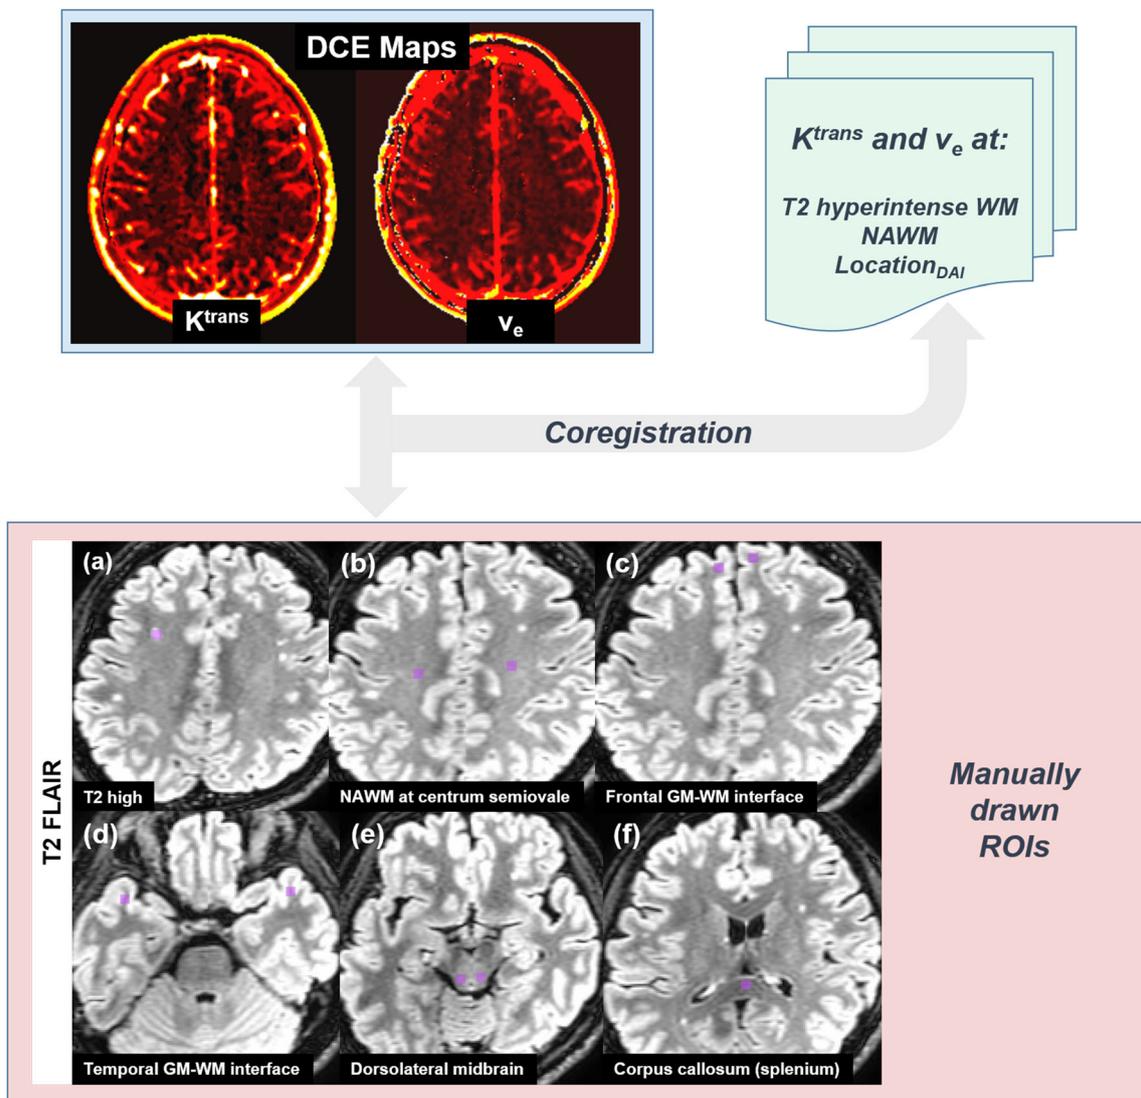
Image analysis of dynamic contrast-enhanced (DCE) MR Imaging. DCE MR imaging pharmacokinetic parameter maps (K^{trans} and v_e) are coregistered with T2 FLAIR images to obtain K^{trans} and v_e values at three manually drawn regions of interests of approximately 30 mm² in size: (1) T2 hyperintense white matter (WM) lesions (a), (2)
